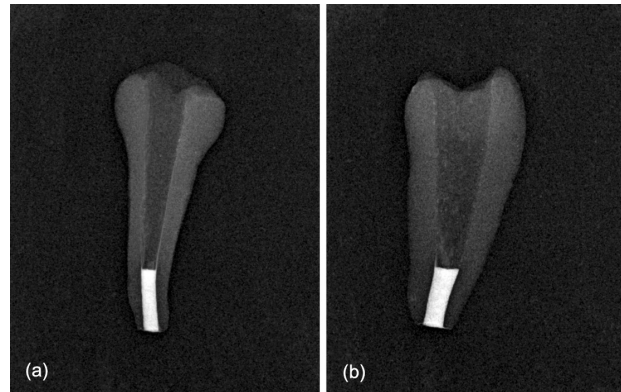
Representative radiographs of MTA apical plugs for void score assessment: (a) buccolingual view, (b) mesiodistal view.
